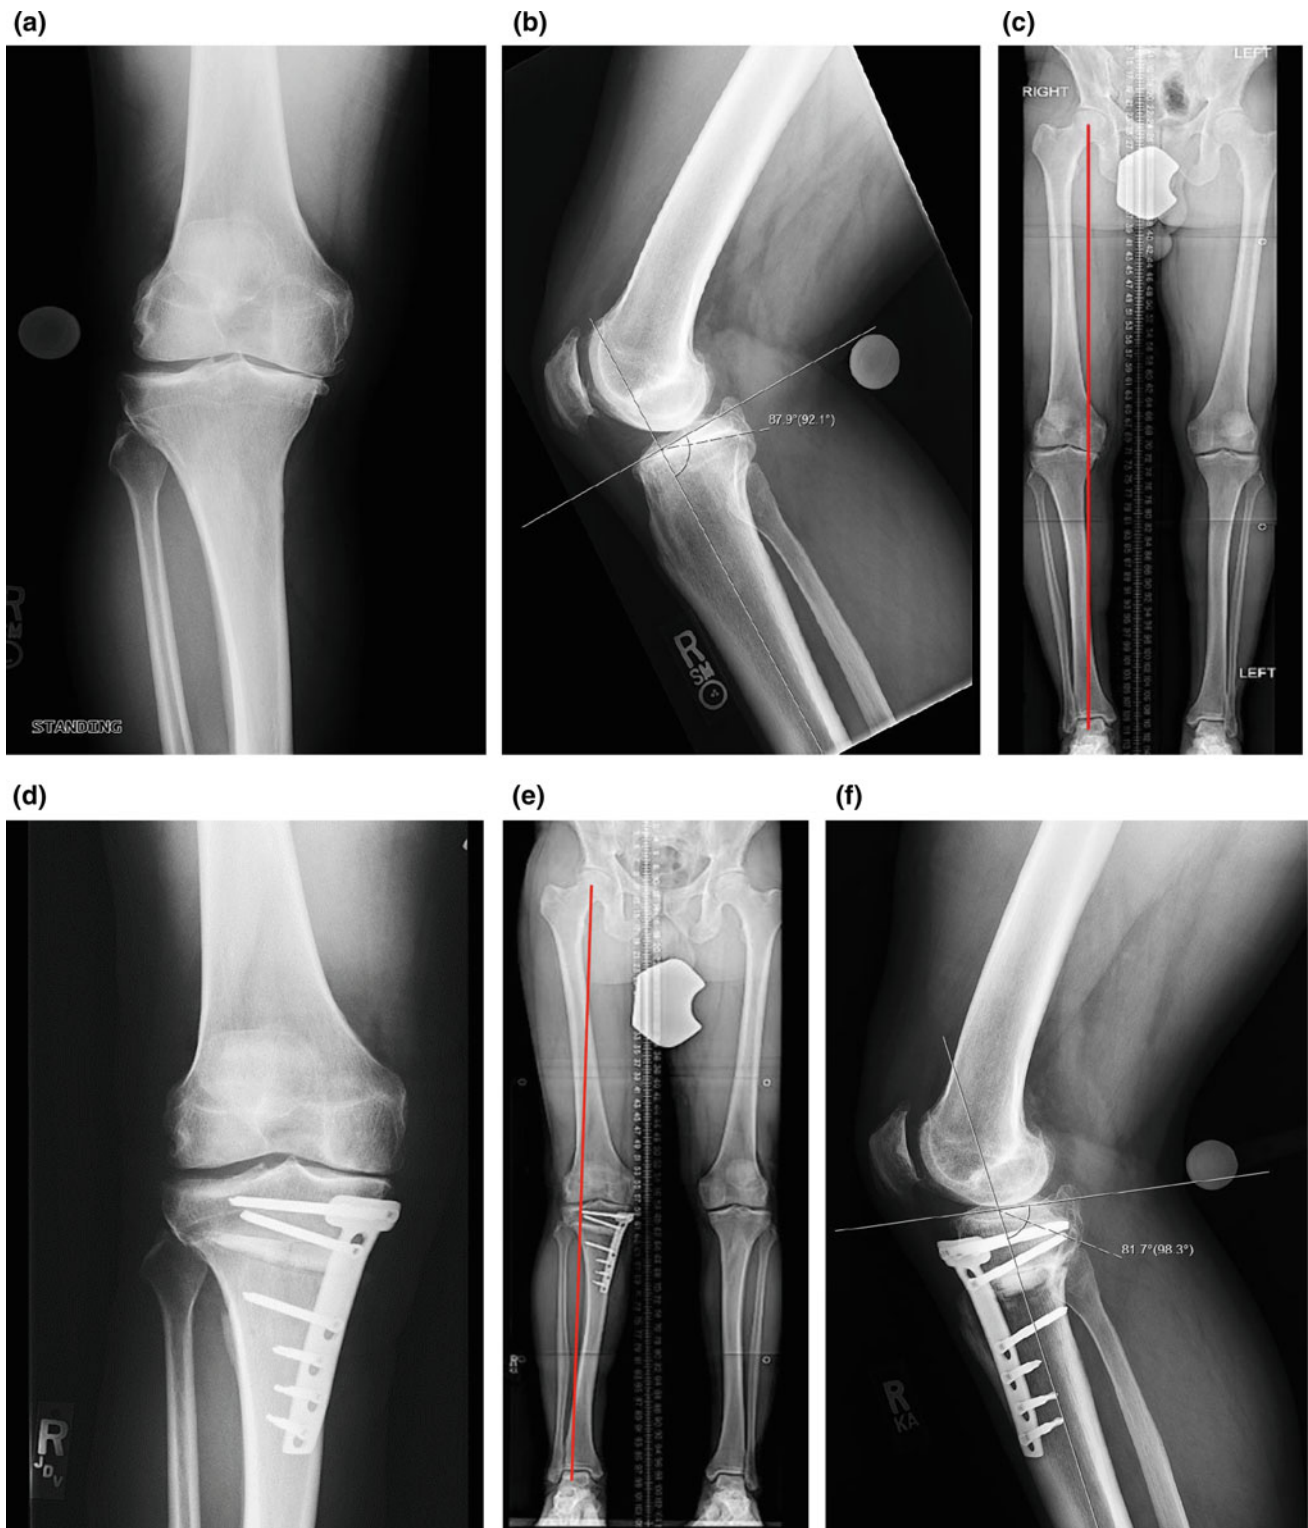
Thirty-five-year-old male with history of PCL deficiency and medial side DJD. a Pre-HTO AP radiograph right knee; b Pre-HTO lateral radiograph right knee showing a 2.1° tibial slope; c Pre-HTO
